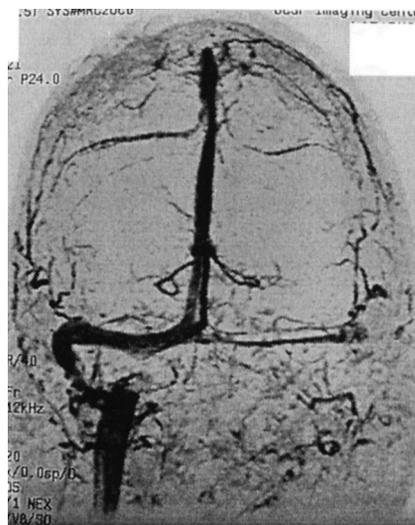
Magnetic resonance angiography/magnetic resonance imaging of dominant transverse sinus and jugular bulb.
